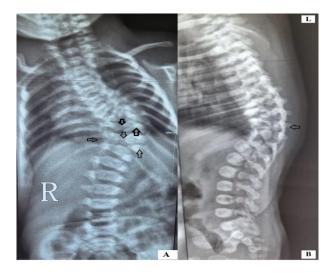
Anteroposterior (A) & lateral (B) views of trunk radiographs showing hemivertebrae of T9 & T11 (up arrows), butterfly vertebrae at T8 & T10 (down arrows), absence of right 11th rib (left arrow), kyphosis peak at T9 vertebrae (right arrow) and scoliosis.
